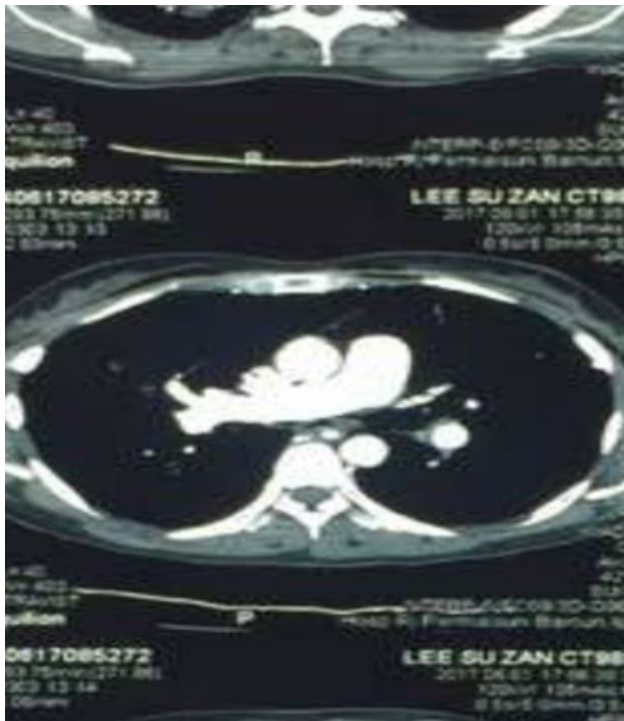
CT demonstrating suspected enlarged bronchial artery
